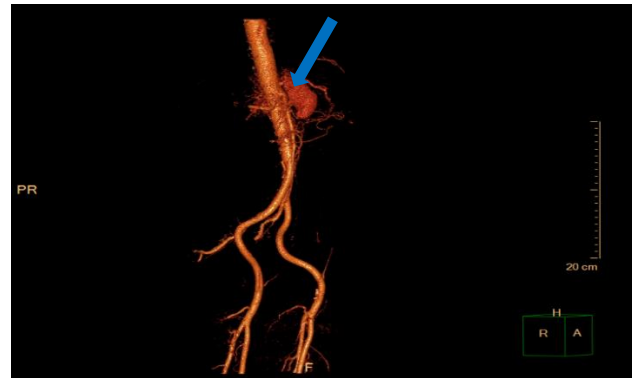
CT angiography (Lateral) demonstrating the entire abdominal arterial vasculature (contained hematoma marked by arrows).
